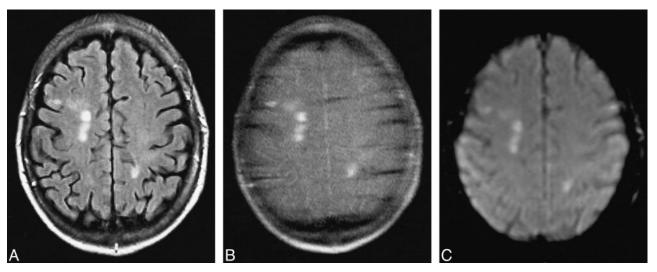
A-C, Axial fast-FLAIR (TR/TE/excitations = 9500/119/1, TI = 2200) (A), HASTE-FLAIR (TE/excitations = 87/1, TI = 2800) (B), and EPI-FLAIR (TE/excitations = 54/1, TI = 2200) (C) images of the brain in a patient with clinically definite MS. The same lesions are seen on all three images.
